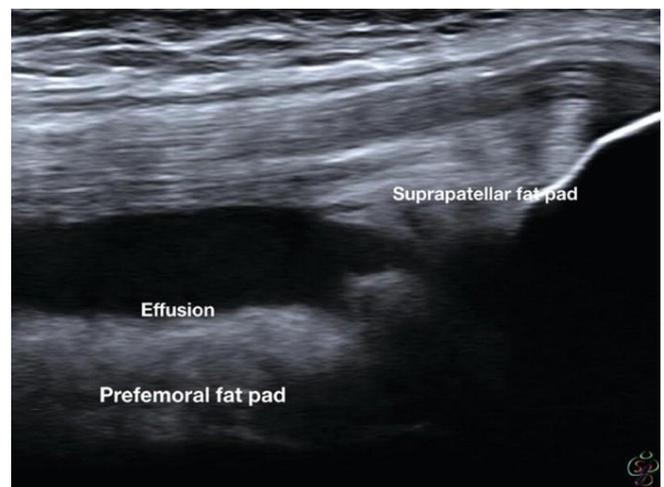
High-resolution ultrasound image of suprapatellar joint effusion
